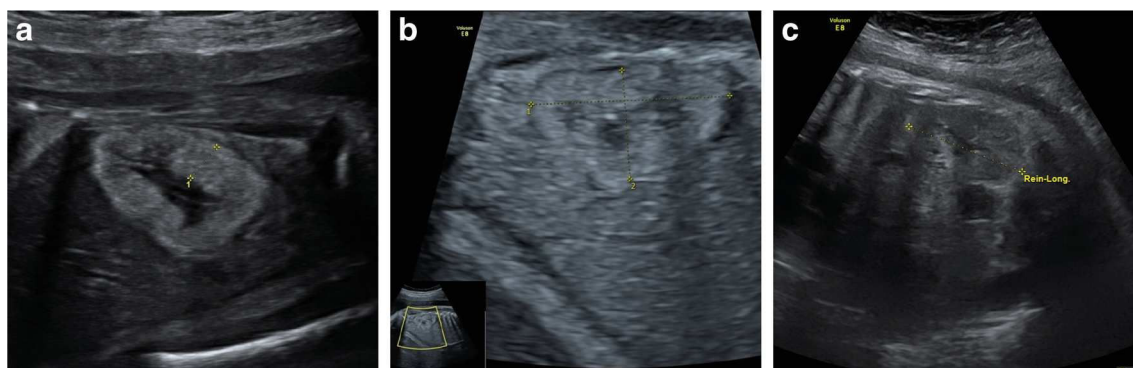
Prenatal ultrasound (US). a Case 1 at 25 weeks of gestation, b case 2 at 27 weeks of gestation, and c case 3 at 36 weeks of gestation (US pictures at first detection for this case were not available)
